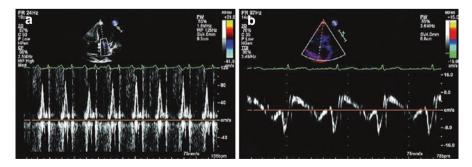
Diastolic abnormalities on echocardiogram. (a) Pulse wave Doppler of the mitral valve inflow in a patient with acute AMR. Increased E/A ratio. The Mitral Valve Deceleration Time measures 61 msec. (b) Tissue Doppler of the septal mitral valve annulus showing reduced e' velocity and reversal of e'/a' ratio
